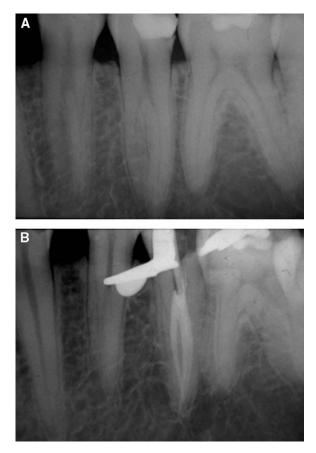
(A) Preoperative radiograph of mandibular bicuspid with trifurcation of canals. (Courtesy Kevin Edwards, DDS, Portland, Oregon) (B) Postoperative radiograph.
